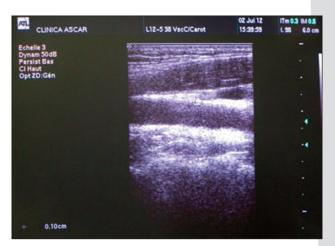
Ultrasound measurement technique of the carotid intima-media thickness (IMT)
